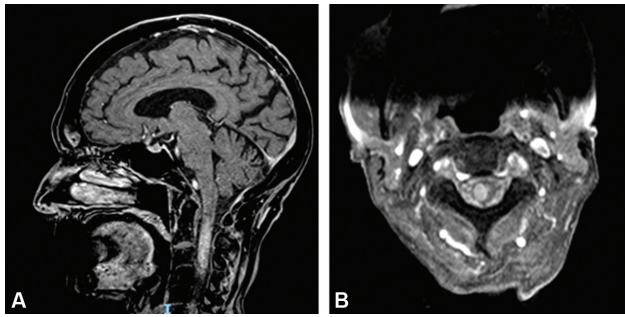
(A) Precorticotherapy sagittal postcontrast magnetic resonance imaging (MRI). (B) Precorticotherapy axial T1 postcontrast.
